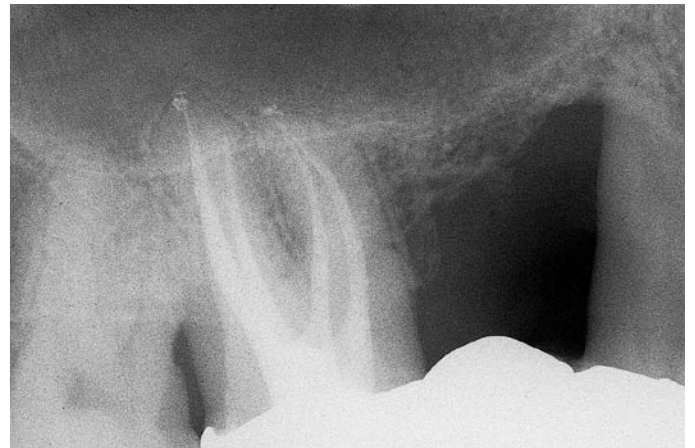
Postoperative radiograph of an upper right first molar with mesiobuccal and mesiopalatal canals joining together at a common foramen.
